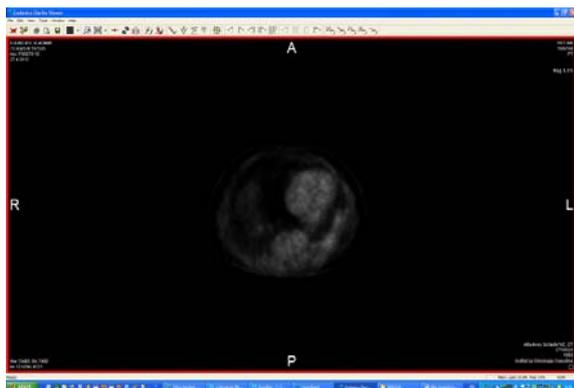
Control results of positron emission tomography/computed tomography (PET/CT) after 3 months without detectable focus of intensive pathological accumulation of ^{18}F -fluorodeoxyglucose (^{18}F FDG).
